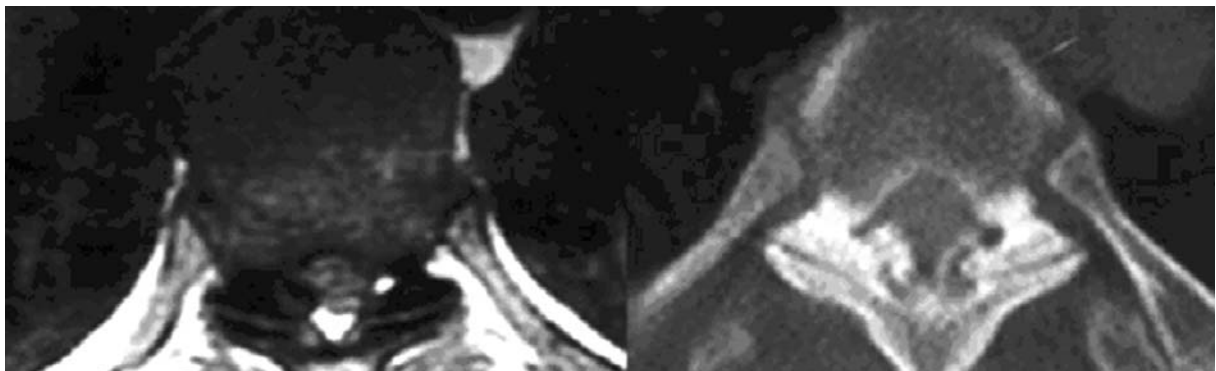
(a) T2-weighted axial thoracic MRI shows narrowing in the spinal due to ossified ligamentum flavum, (b) axial sectioned thoracic CT shows ossified ligamentum flavum.
